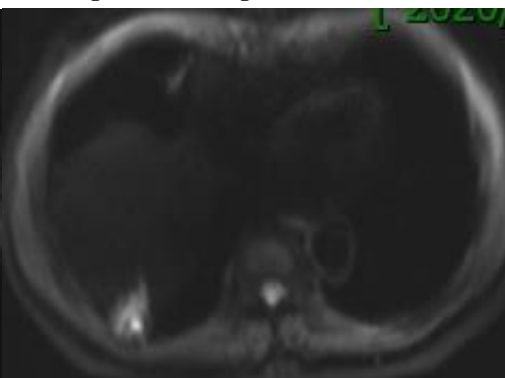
DWI image of adenocarcinoma.
